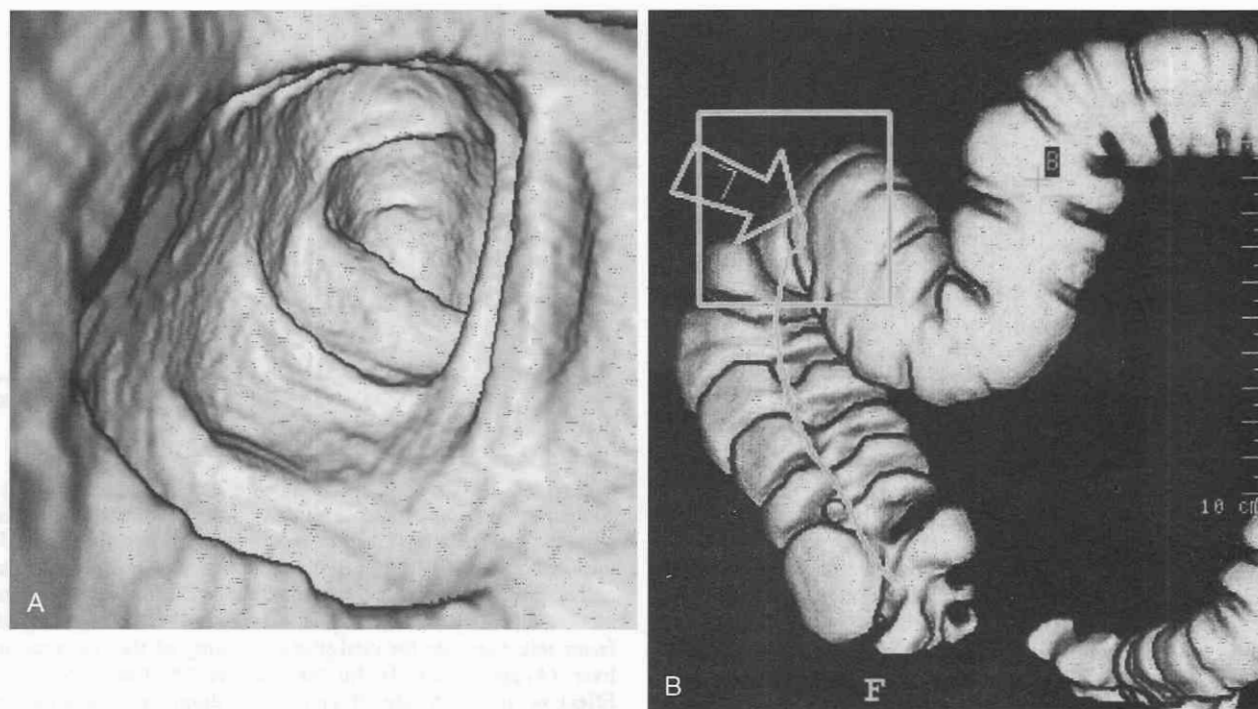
Virtual colonoscopy. Multislice helical CT was performed with 2.5-mm slice width after rectal insufflation of 2 L of carbon dioxide. A, This normal virtual endoscopy image was taken from the top of the hepatic flexure looking down into the proximal transverse colon. B, The overview image shows the viewer's position (open arrow) in A.
